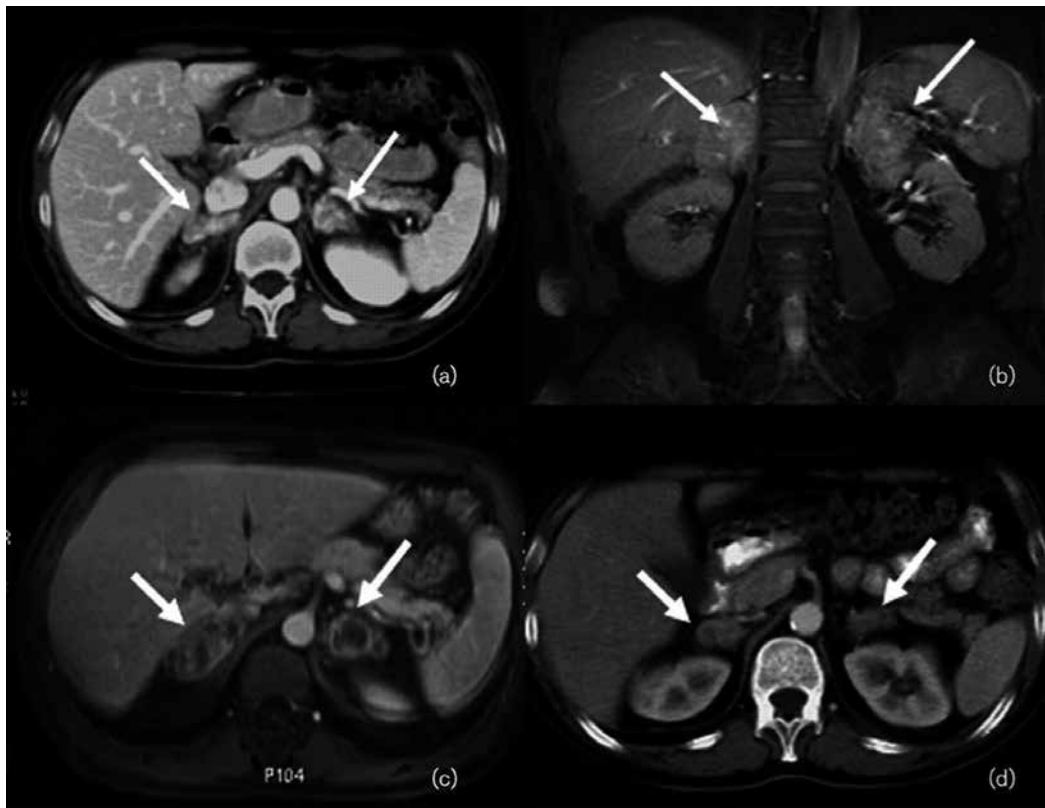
Radiological features of adrenal tuberculosis. (a) Adrenal enlargement with high contrast uptake and rim enhancement demonstrated on CT scan; (b) Adrenal enlargement shown on a coronal FS T1 MRI scan; (c) Adrenal enlargement shown on an axial FS T1 MRI scan; (d) Significant reduction of the volume of the adrenal glands with no pathological contrast uptake on a CT scan after treatment. (Courtesy: Ref. [4].)
